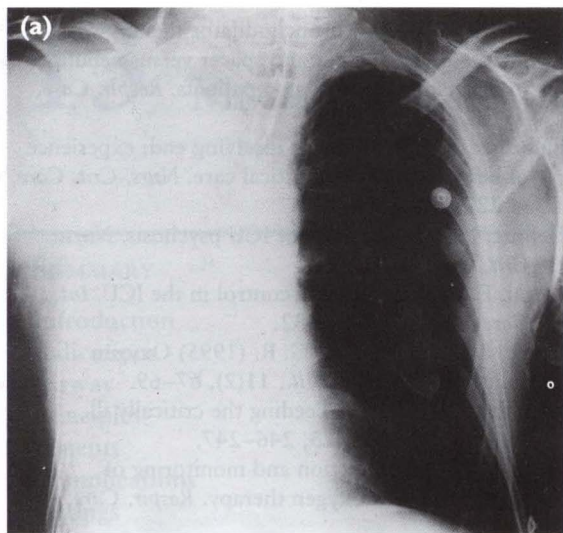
X-ray of Mr FA before and after physiotherapy.
